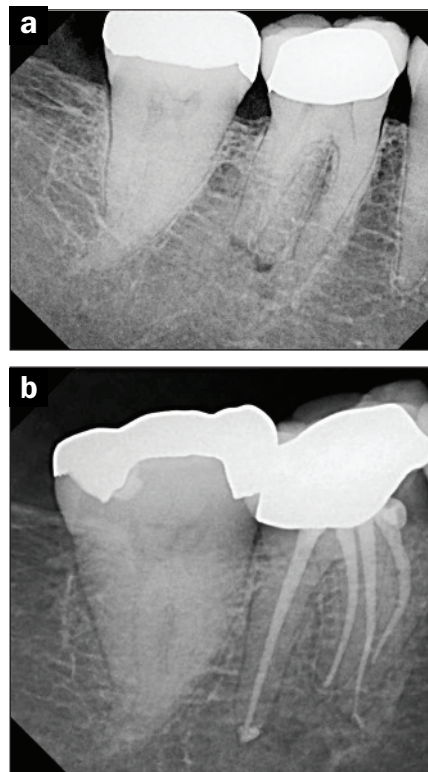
Conventional case completed with one cone bioceramic technique: (a) pre-op x-ray and (b) post-op x-ray.
